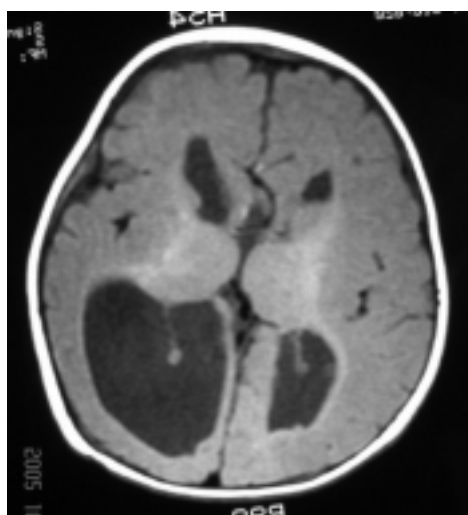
MRI of a girl with developmental delay, hypotonia, infantile spasms, and retinal lacunae (Aicardi syndrome) showing absent corpus callosum.
